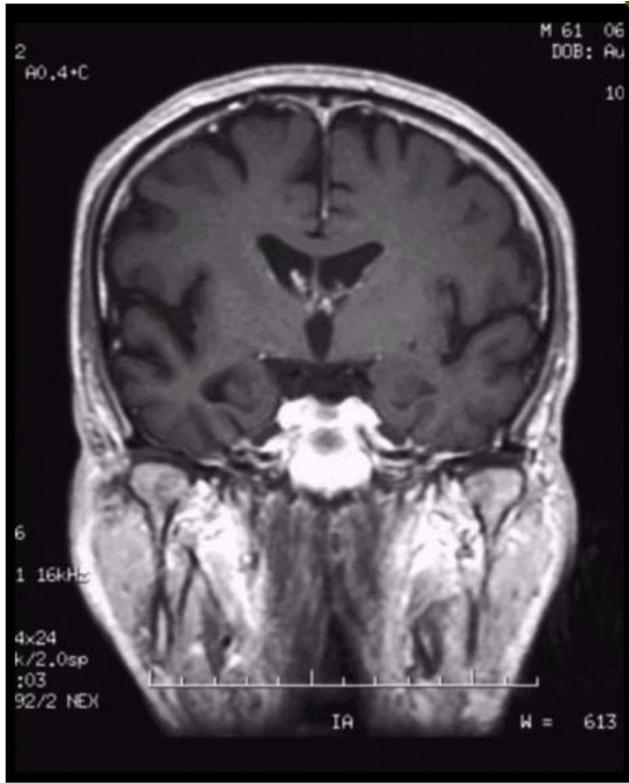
Coronal, T1-weighted MRI scan of patient's brain. Brain image shows hippocampal atrophy located mostly on the right hemisphere of the brain.
